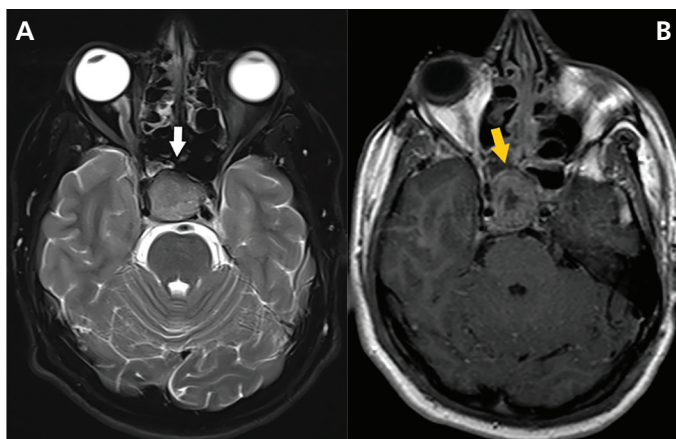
A hyperintense macroadenoma on the axial T2-weighted image, B. A heterogeneously enhanced macroadenoma on the post-contrast image
